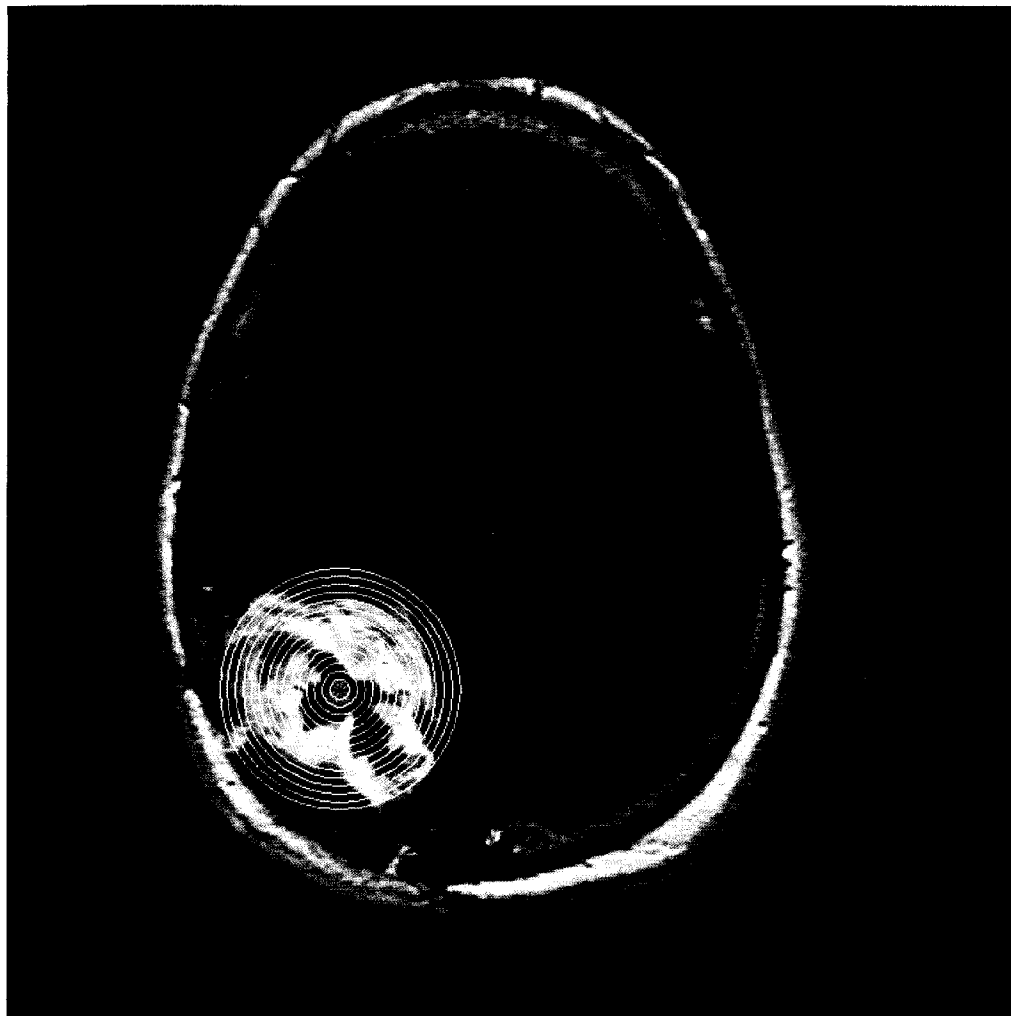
The concentric annular model of angiogenesis quantification. Shown here is the post-contrast T1-weighted image of a subject (patient 1) with a GBM. The red asterisk denotes the centroid of the tumor, while the yellow concentric circles represent the annuli of increasing radii, used to compute various parameters utilized in this study.
